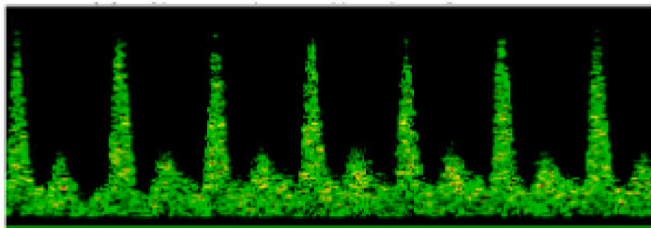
A typical wrist pulse doppler spectrogram [35].
